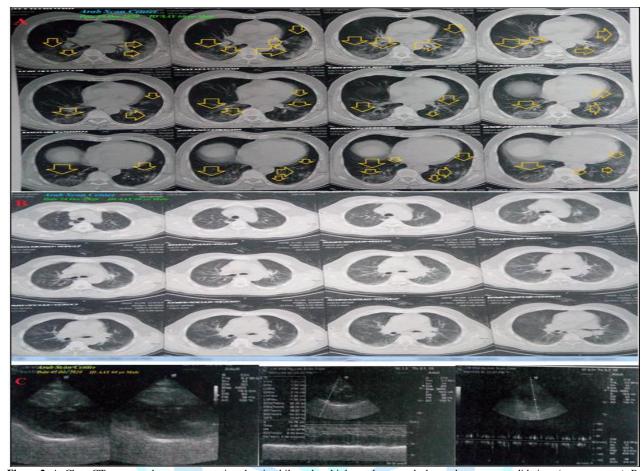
A: Chest CT scan was done on presentation showing bilateral multiple patchy ground-glass pulmonary consolidations (orange arrows); B: Chest CT scan was done within 20 days of the presentation showing nearly dramatic improvement of the above ground-glass consolidations. C: Echocardiography was done on the second day of the presentation showing no abnormality detected with an EF of 58%.
